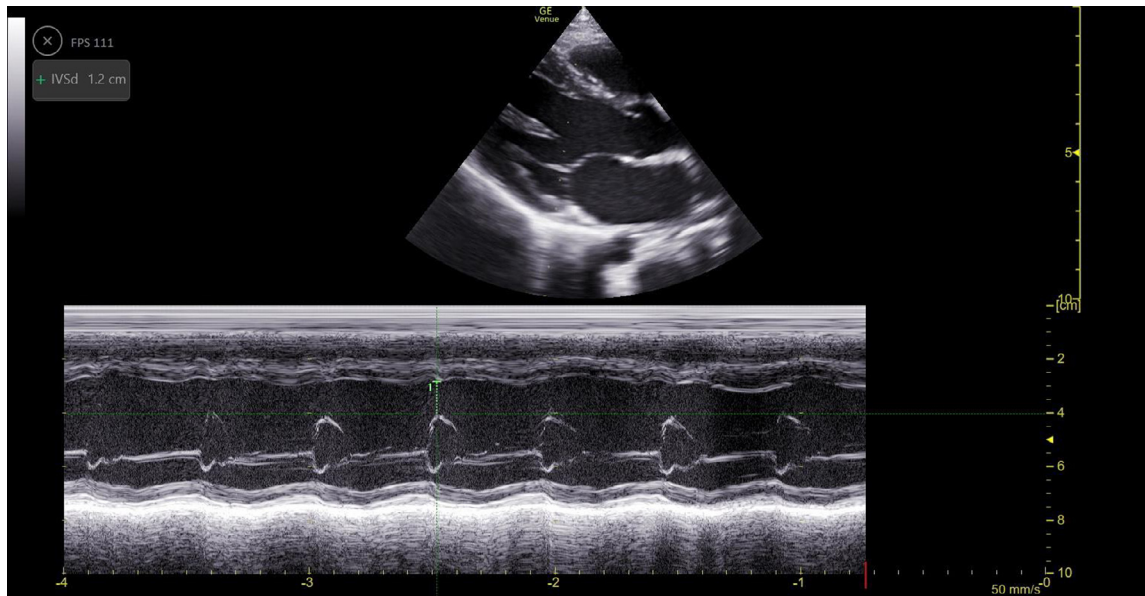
Cardiac point-of-care ultrasound examination: Using the E-Point Septal Separation method, this image displays the M-Mode of the cardiac parasternal long axis view with mitral valve at maximum excursion far away from the interventricular septum demonstrating depressed cardiac function in a 5-year-old male (24–26).
